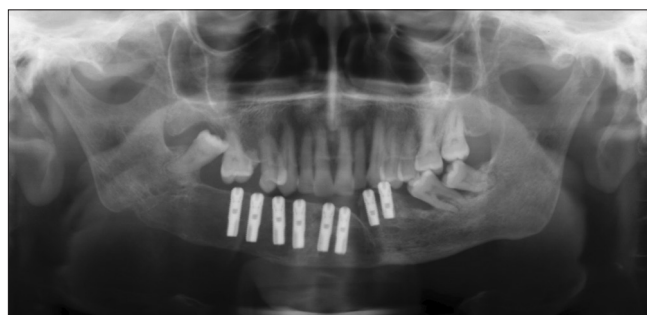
Radiographic control of the implant positioned
